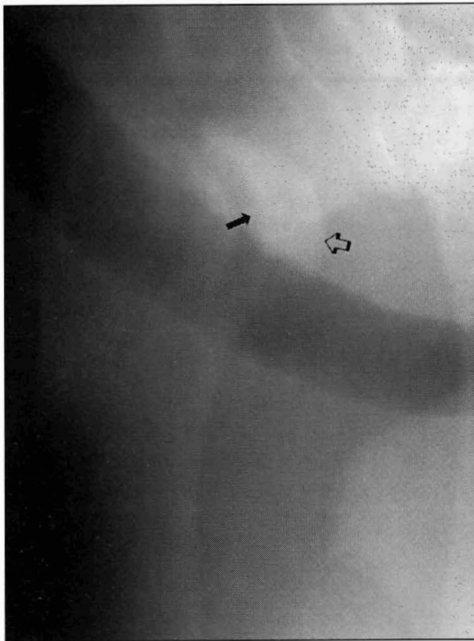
Same radiographic view as Figure 1. Notice the incongruity between articular surfaces of the humeral head and glenoid cavity. The articular surface of the humeral head (open arrow) can be seen above the articular surface of the glenoid cavity (closed arrow).
